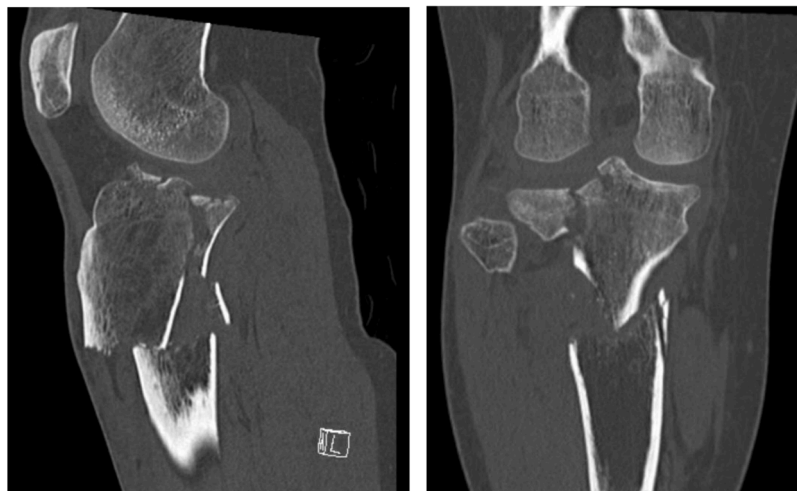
Case example: 46-year-old patient with a bilateral fracture type Schatzker VI. Preoperative CT scans of the fracture.
